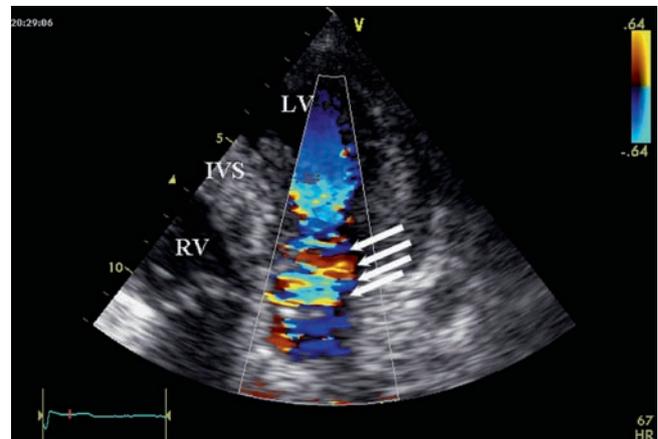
Apical five-chamber view in hypertrophic obstructive cardiomyopathy. Colour Doppler mapping in systole shows flow acceleration and turbulence in the LV outflow tract (arrows). *IVS*: ventricular septum; *LV*: left ventricle; and *RV*: right ventricle
